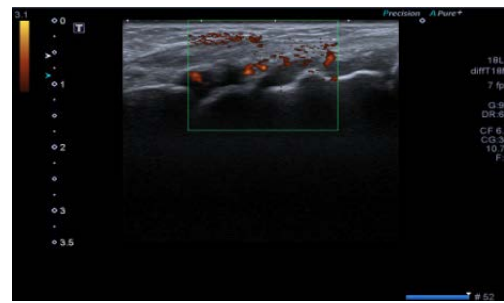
Ultrasonographic longitudinal scan of the Rt. 2nd MCP showing grade II synovial thickening (Lt. photo) and of wrist joint showing grade 3 synovial thickening and grade 2 Doppler signal (Rt. photo).
